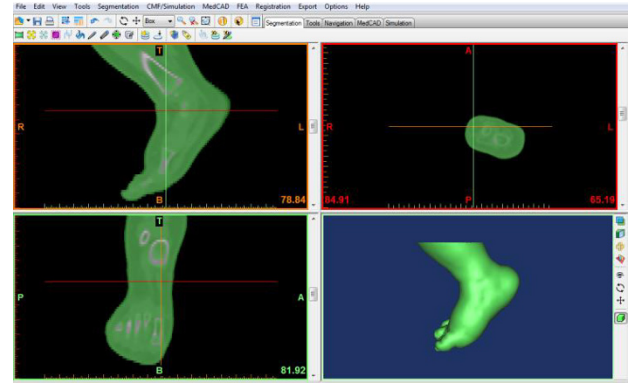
CT images exported to MIMICS
